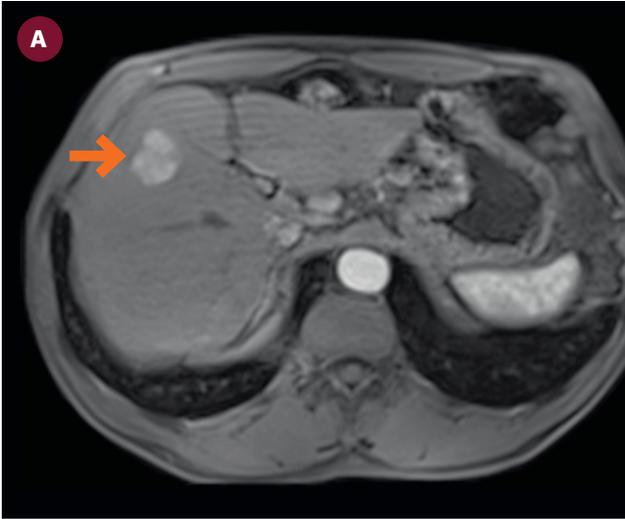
Gadolinium-enhanced MR imaging in the arterial phase demonstrates vascular enhancement of the lesion (arrow).
